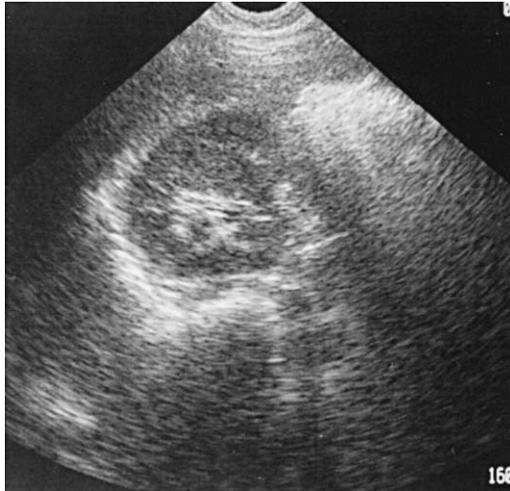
Transverse (short-axis) view of normal kidney. Note the echogenic white Gerota's fascia, the grainy gray renal cortex, and the central echogenic pelvicalyceal structures. (From Brown DFM, et al. Renal ultrasonography. *Emerg Med Clin N Am* 1997;15:887; with permission.)
